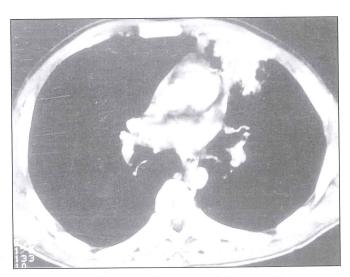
Thorax CT: A consolidation area on the left upper side.
